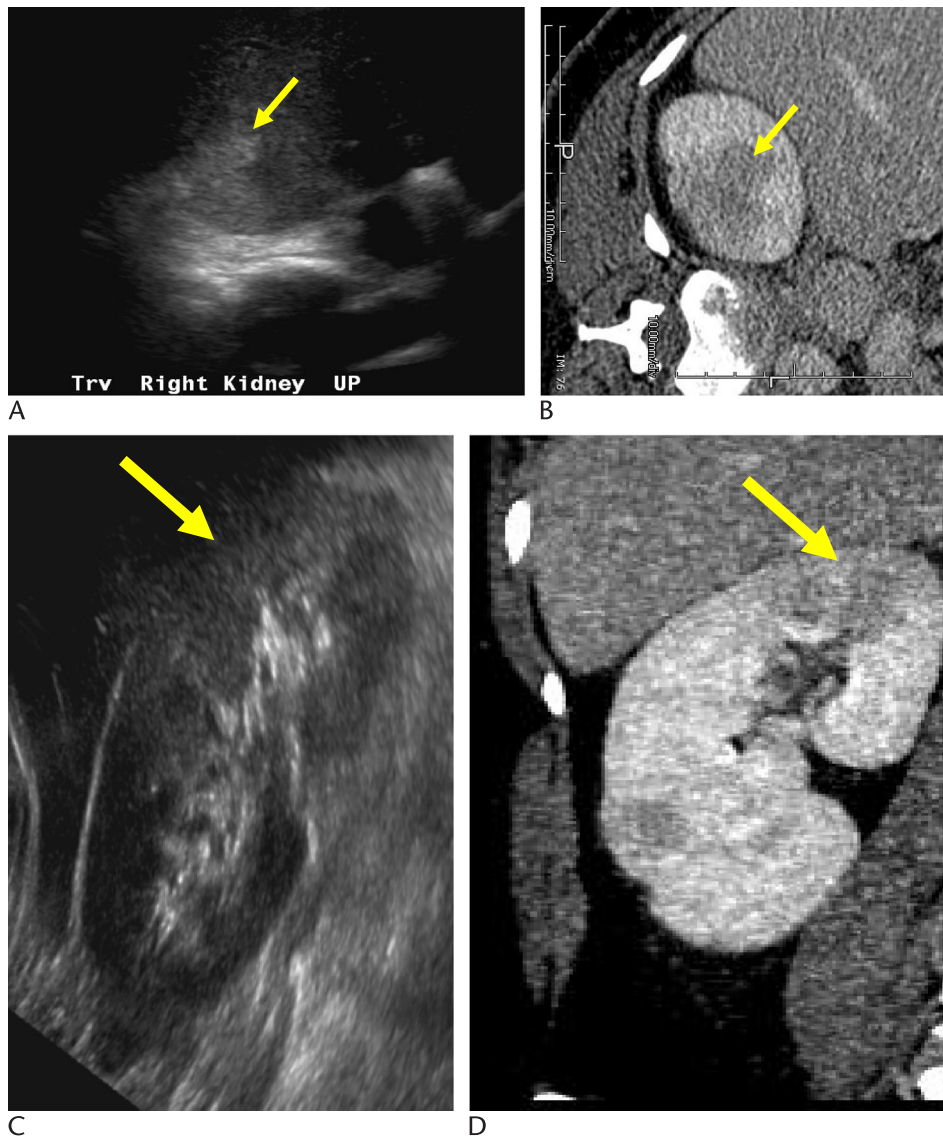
Transverse US (A), transverse CECT (B), sagittal US (C), and coronal-reformatted CT (D) images of the right kidney demonstrate focal echogenic regions on US (A, C) in the upper pole renal parenchyma with loss of corticomedullary differentiation and corresponding areas of decreased enhancement on postcontrast CT (B, D). Orientation of the axial CT and longitudinal US are rotated to match the corresponding other modality. (An additional smaller focus of decreased enhancement is seen in the lower pole of the kidney on the coronal reformatted CT image [D]).
